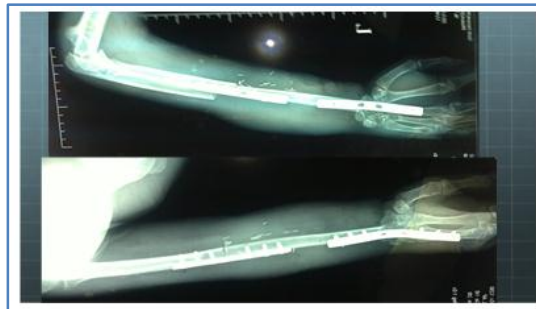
Post-operative picture x-ray well settled bone flap
